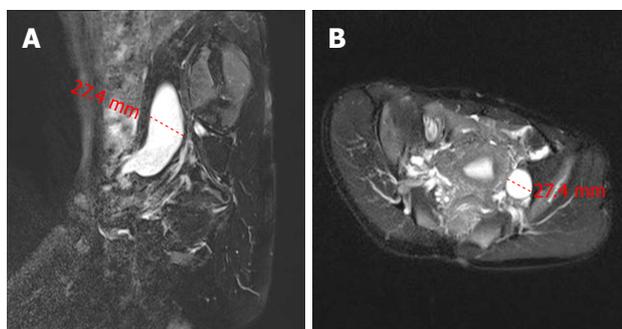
Imaging of left external iliac vein malformation in the patient. A: MRI sagittal image of the left iliac vein; B: MRI coronal image of the left iliac vein (red dotted line marking the widest point of the vein, measuring approximately 27.4 mm). MRI: Magnetic resonance imaging.
